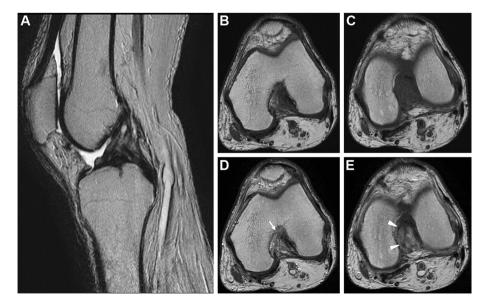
Postoperative magnetic resonance imaging. Postoperative T2-weighted sagittal image showed a reduction of ligament expansion with normal ligament intensity (A). Postoperative T1-weighted axial image (B, C). Postoperative T1-enhanced axial image showed contrast effect at the posterior cruciate ligament proximal intercondylar femoral attachment side (arrow) (D) and tibial attachment side (arrow head) (E).
